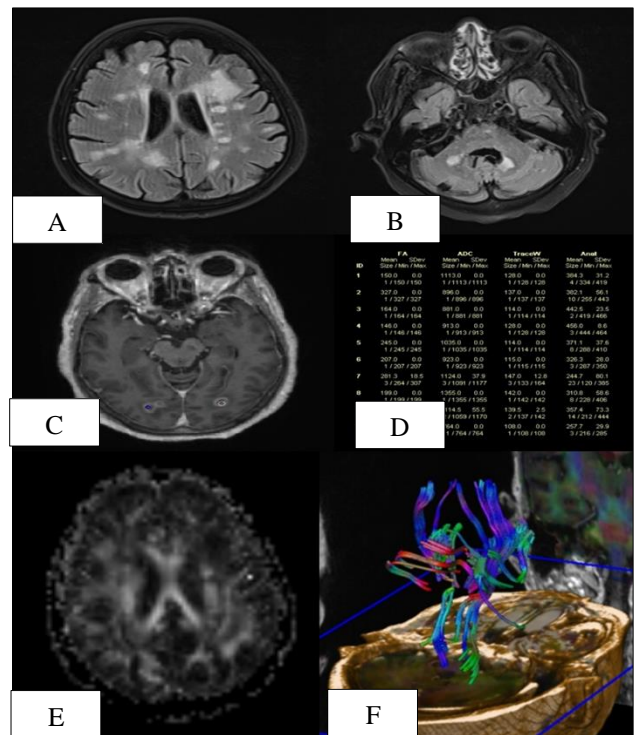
ADEM. Axial FLAIR image of brain (A, B) multiple hyperintense demyelinating lesions in bilateral corona radiata and cerebellar white matter (yellow arrow). (C) ROI plotted on enhancing lesion (D) FA and ADC chart. Demyelinating lesions appear dark on FA map, green circle (E) 3D tractography image (F) loss of bilateral white matter fibres (red arrow).
